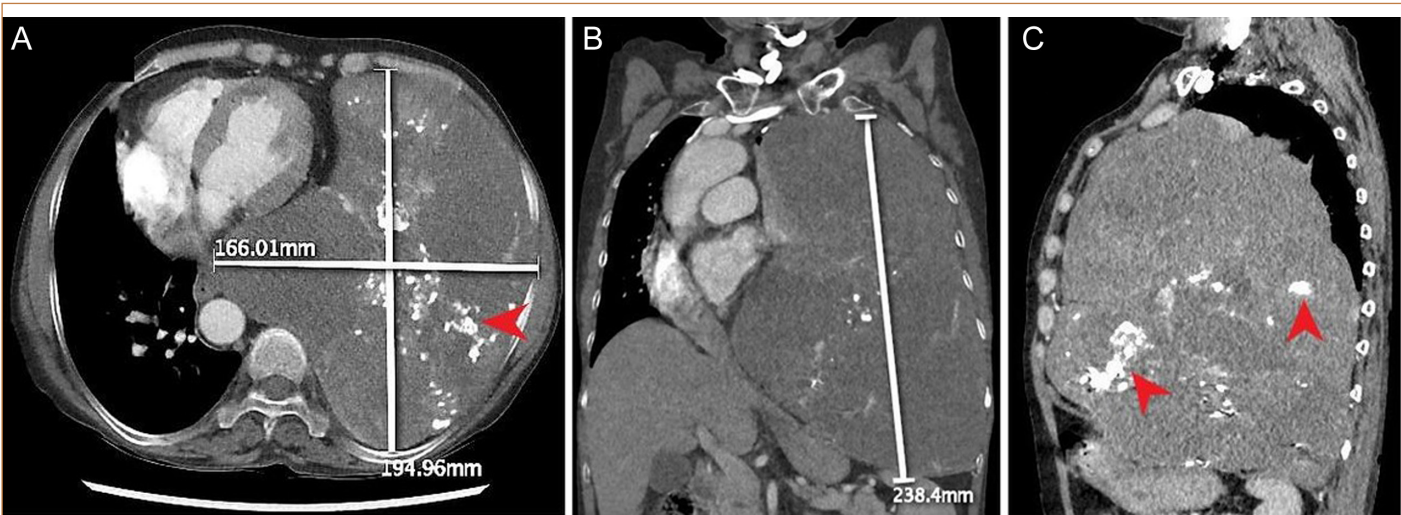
High-resolution CT scan showing a large, well-defined, isodense mass in left hemithorax of size 19.5 cm × 16.6 cm × 23.8 cm, with nodular-chunky calcifications (red arrowheads). CT, computed tomography.
